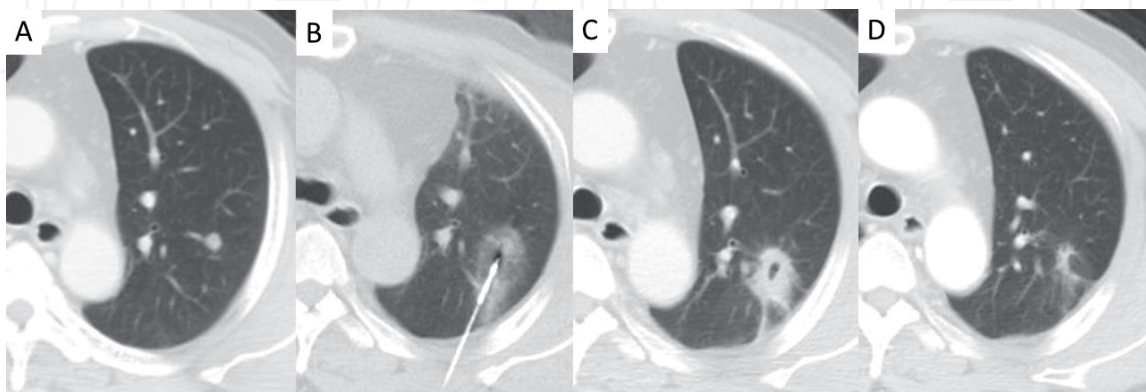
(A) CT scan shows a biopsy proven left upper lobe lung metastasis in a patient with stage III colonic cancer who was treated with colectomy and chemoradiation previously. (B) CT-guided radiofrequency ablation of the lung metastasis was performed with ablation catheter in-situ and an area of surrounding ground glass opacities (GGO). (C) The ablated area evolved into a denser GGO with central cavitation at 1 month after ablation. (D) CT scan at 6 months after ablation showed evolution of the ablated area into a smaller contracted scar with no signs of recurrence.
